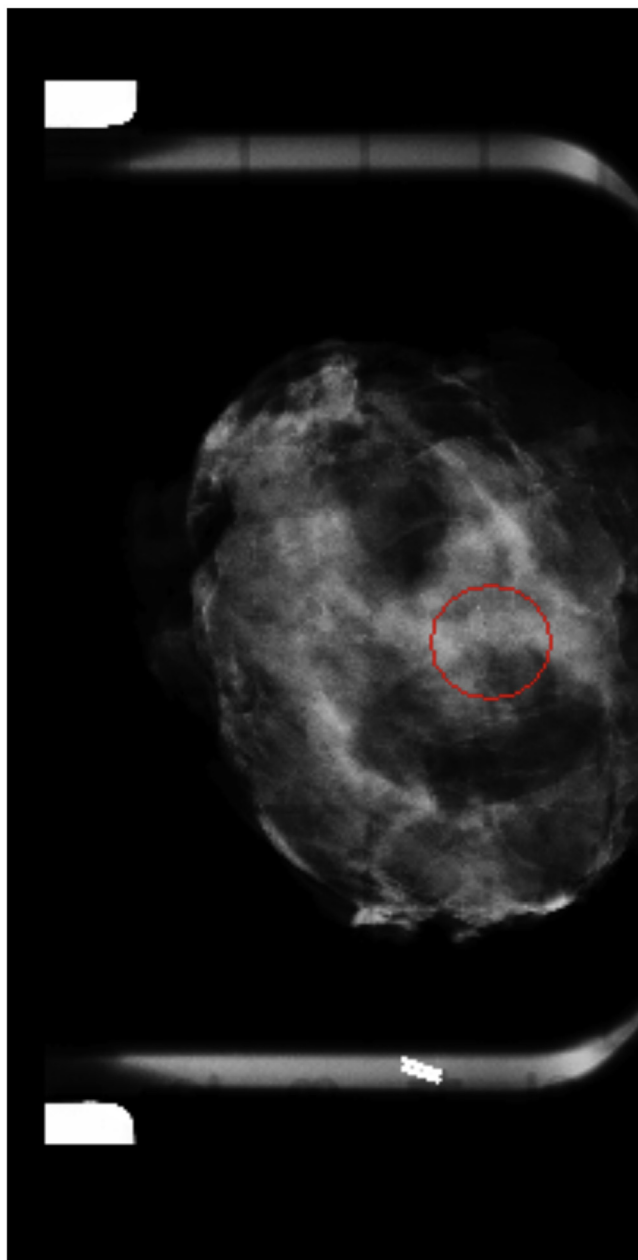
Radiographic examination showing the radicality of the supero-central lumpectomy.
